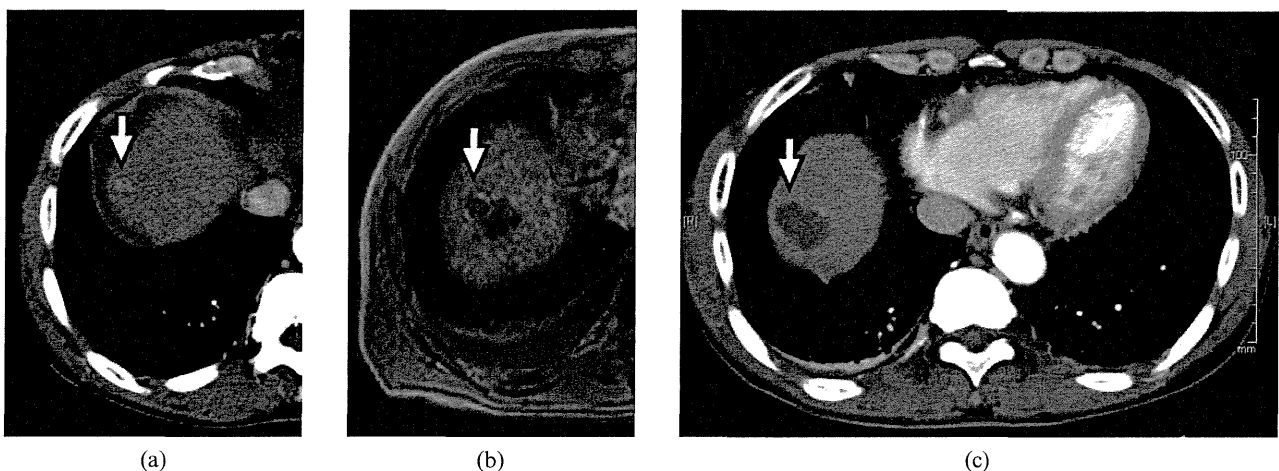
A 65-year-old male with a 12 mm hepatocellular carcinoma in liver segment VIII. (a) Enhanced CT (arterial phase) reveals a hypervascular tumour (arrow). (b) Post-ablational MRI demonstrates obvious discontinuity of the low-intensity rim with tumour protrusion [margin (-)] (arrow). (c) Enhanced CT (arterial phase) 1 month after radiofrequency ablation reveals no residue with insufficient ablative margin.
